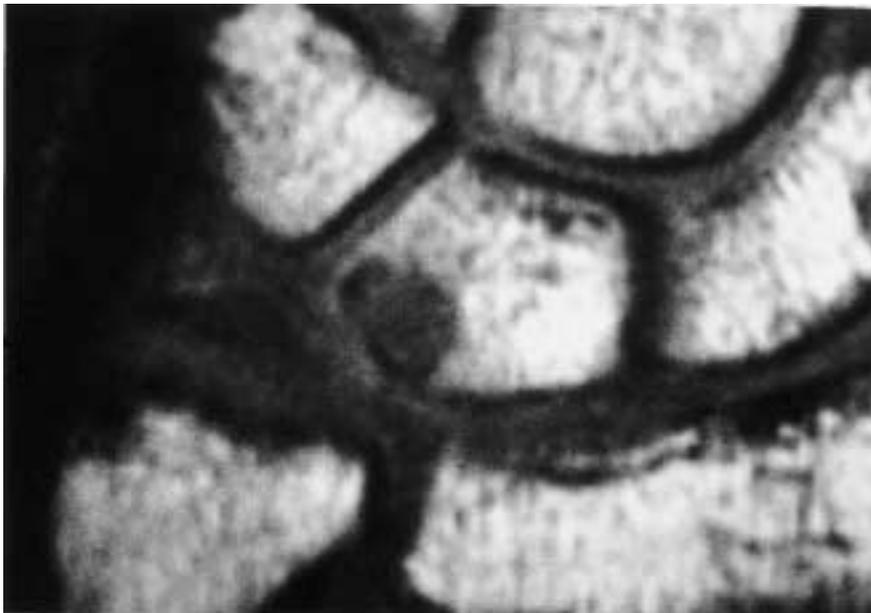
Typical T1-weighted magnetic resonance image of advanced ulnar impaction syndrome. Low signal intensity at the ulnar base of the lunate is evident, but this finding is absent in most patients with ulnocarpal impaction syndrome.
